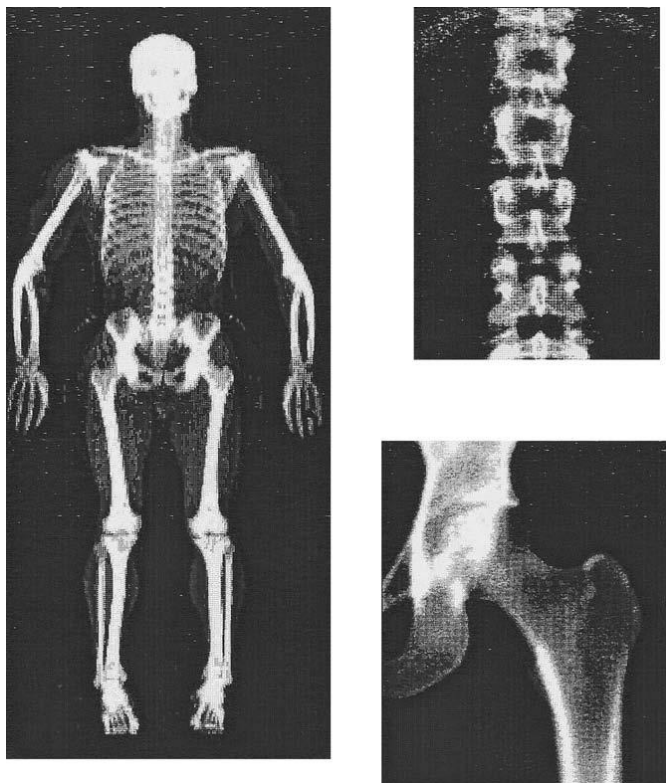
Total body, spine, and hip scan images obtained using dual-energy X-ray absorptiometry.
